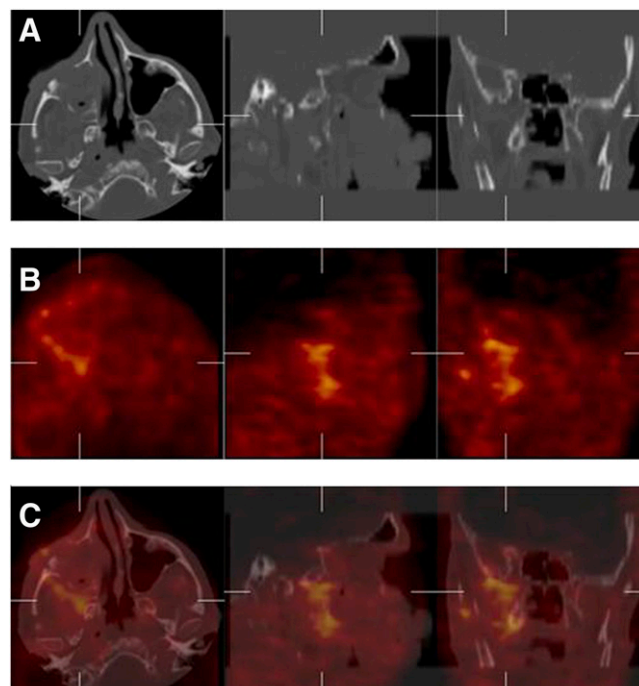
A 65-y-old patient with clinical suspicion of local relapse from previously resected sclerosant basocellular epithelioma in right nasogenian fold. Patient underwent right maxillary antrectomy. (A) CT images show surgical sequel at roof of right maxillary sinus with mucosal thickening of cavity. (B and C) ^{99m}Tc -glucarate shows intense uptake (B) that in fusion images corresponded to location of pterigomaxillar fossa (C). Lesion was further confirmed as local relapse by biopsy.
